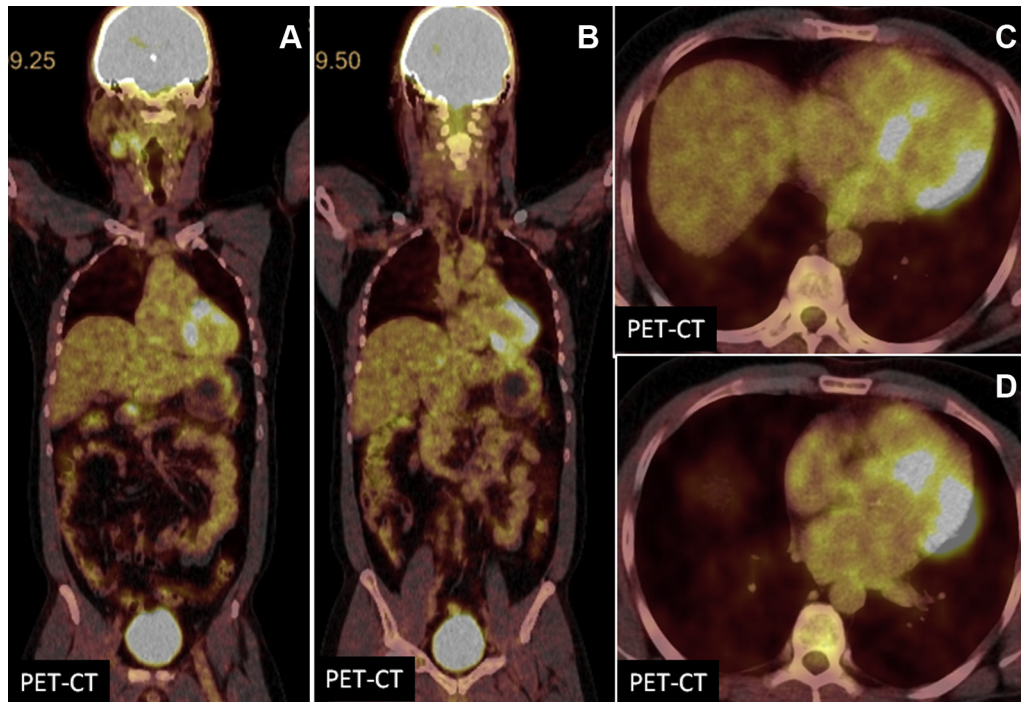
Fused coronal (A, B) and transversal (C, D) 18F-FDG PET/CT images after application of 276 MBq 18F-FDG in a patient with LE. Note the different signal intensity in the LV myocardium due to heterogeneous uptake related to the disease. No significant increase of metabolism is shown in other organs.
